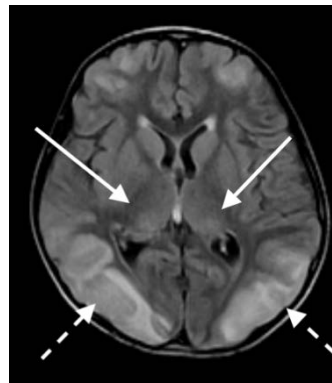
Atypical PRES case. FLAIR MR sequence shows bilateral thalamic hyperintensity (arrows) and bilateral symmetric parietotemporal cortical and subcortical hyperintensity (broken arrows).
